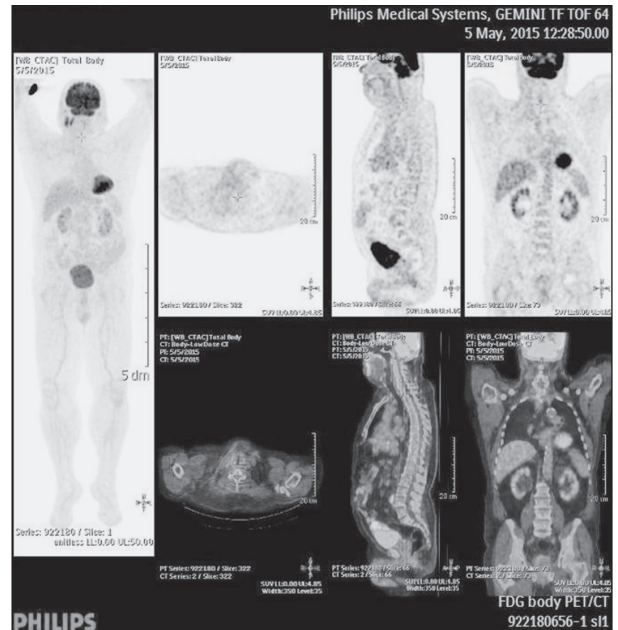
Follow up PET/CT 6 months after the operation.
